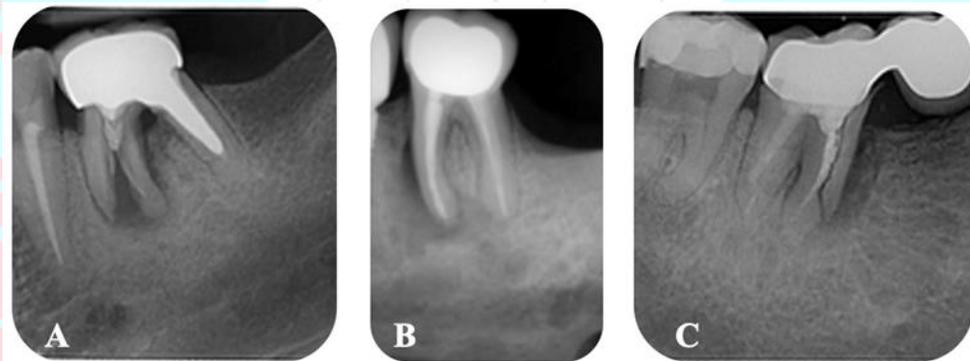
A-C The radiographic observation of mandibular molars (#36, #36, #47) with VRF shows that the line crosses the level of the alveolar bone in the apical direction in the radiographic observation.
